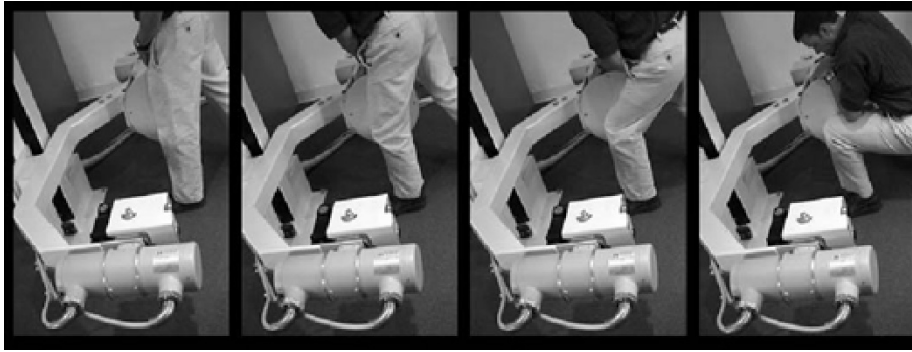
Single plane fluoroscopy allows the patient free motion in the plane between the X-ray source and the image intensifier.
